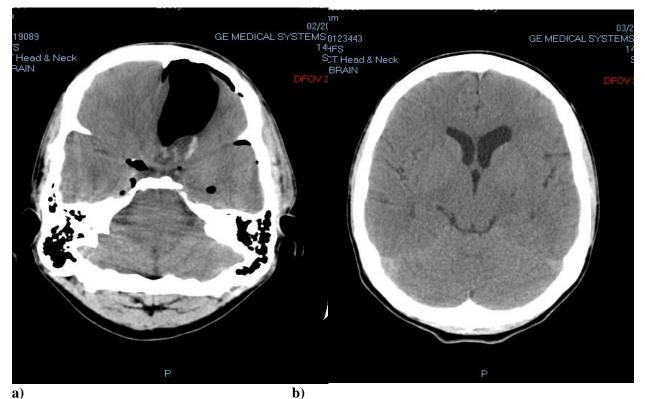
TBI presented by fracture base (ACF), Pneumocephalus and hyponatremia a) preoperative b) postoperative CT brain.
